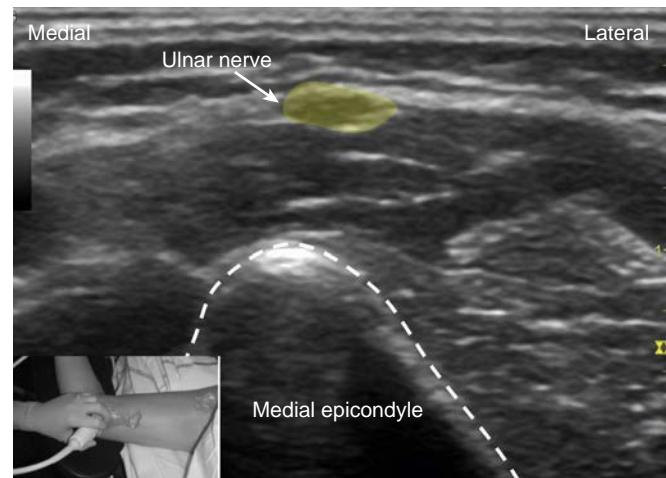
Ultrasound view of ulnar nerve at the elbow.
